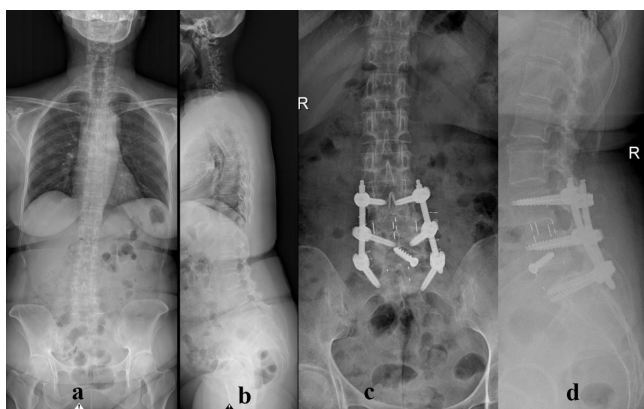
a,b – Anteroposterior (AP) view and lateral view radiograph of the patient prior to oblique lumbar interbody fusion with gross sagittal imbalance; c,d – AP and lateral view lumbar radiograph after patient underwent oblique lumbar interbody fusion.
